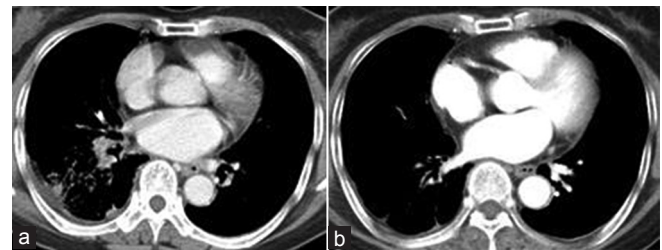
(a) Computed tomography of Case 1: Nonsmall cell lung cancer patient before tyrosine kinase inhibitor treatment. (b) Computed tomography of Case 1: Nonsmall cell lung cancer patient after tyrosine kinase inhibitor treatment
